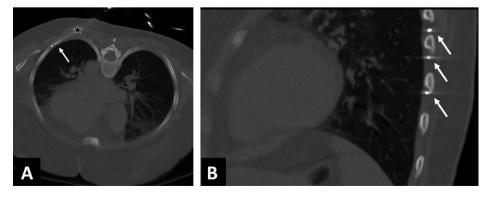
40-year-old woman with intractable neuropathic pain related to previous radiation to thoracic rib metastases. A. Intraprocedural CT image obtained in the axial plane demonstrates placement of the cryoablation probe (star) in the intercostal space (arrow). B. Intraprocedural CT image obtained in the sagittal plane shows three cryoablation probes placed in the intercostal spaces (arrows) corresponding to patient's pain.
